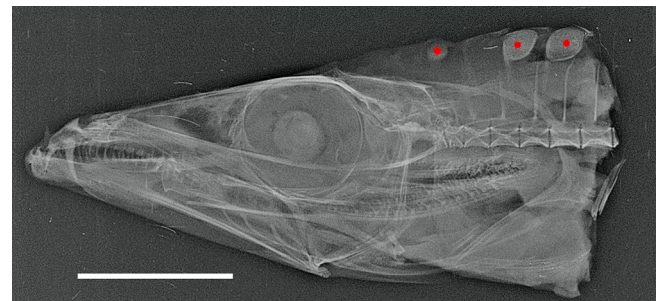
Hyperostotic dorsal-fin pterygiophores on a radiographed head of a silver scabbard fish (*Lepidopus caudatus* (Euphrasen, 1788), SL: 790 mm, Trichiuridae). Hyperostotic structures are marked by red dots. Scale bar = 50 mm.
